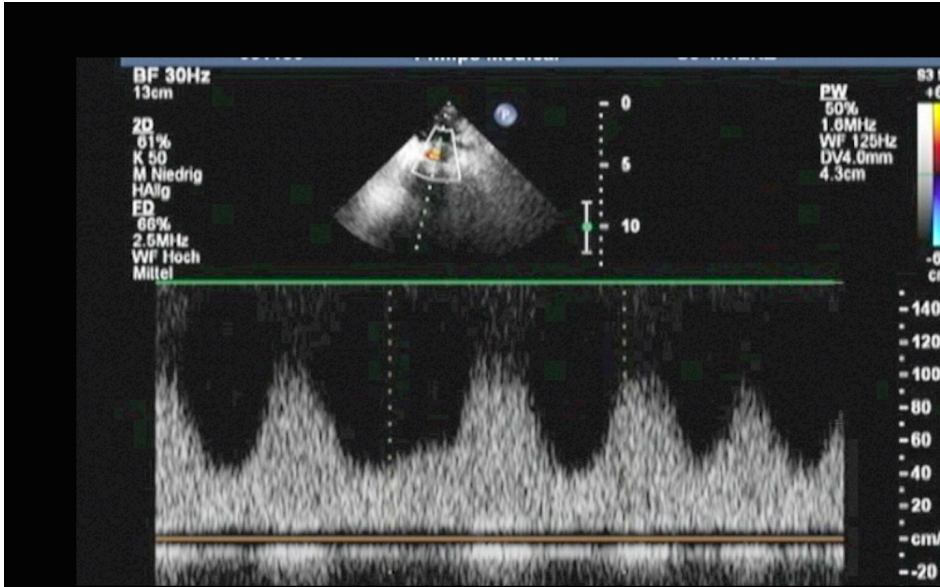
Doppler analysis of outflow cannula
